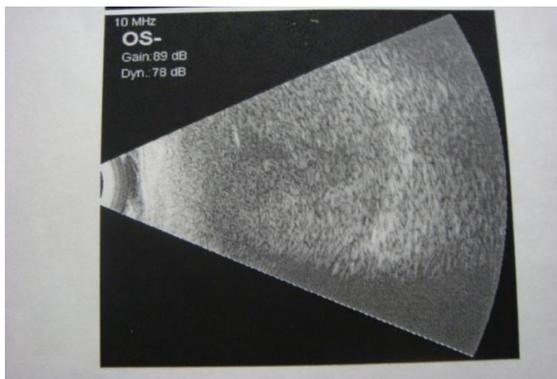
B scan ultrasonography revealed Endophthalmitis.
